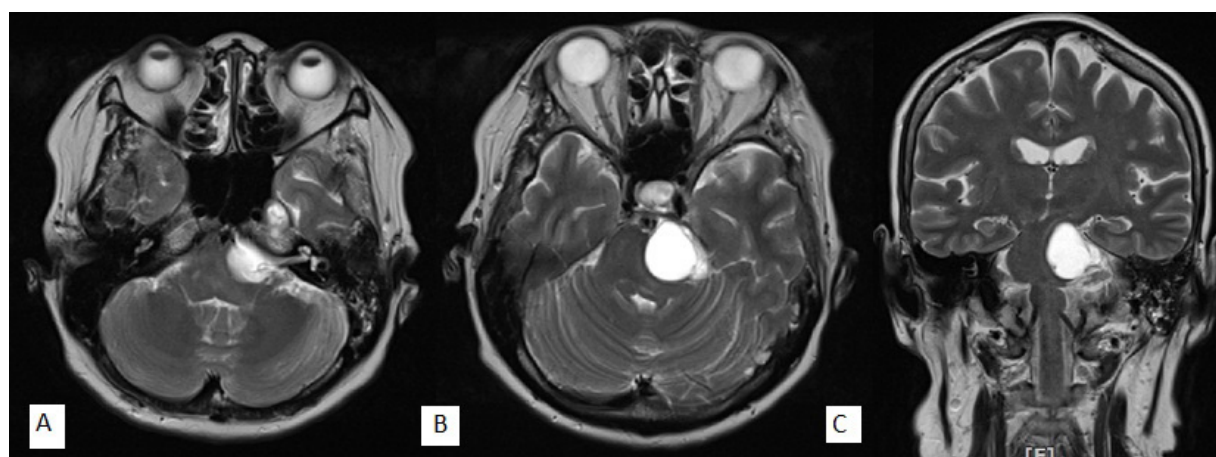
(A) MRI axial view showing tumour occupying the left cerebellopontine angle; (B) A more rostral axial view showing the same tumour compressing the adjacent pons; (C) MRI coronal view showing tumour compressive effect on the brainstem. The tumour measured at 2.8 cm (W) × 2.7 cm (H) × 3.5 cm (AP). The tumour lies superior and medial to the left internal auditory canal without any extension into the canal. The pons, left middle cerebellar peduncle and the 4th ventricle are compressed by the tumour without any hydrocephalus or significant midline shift.
